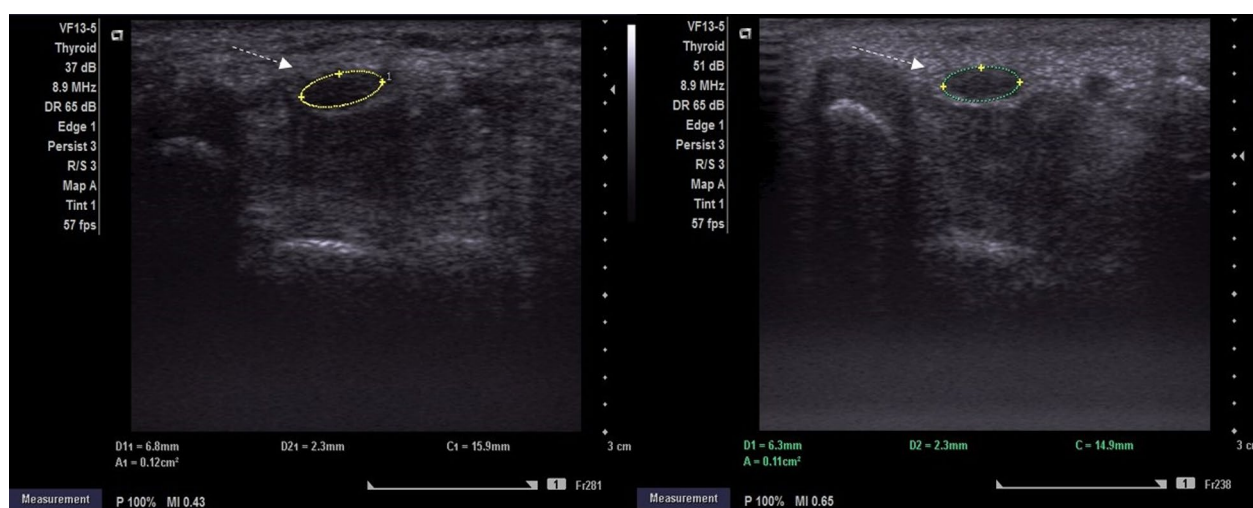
Ultrasound image of the median nerve (dashed arrows) of a 49-year-old patient with mild CTS treated with blind (non-guided) steroid injection. Median nerve CSA and FR before (left image) and 4 weeks after steroid injection (right image). Ultrasonographic improvement was recorded as a slight decrease in CSA (11 mm² vs. 12 mm²) and FR (2.73 vs. 2.95)
